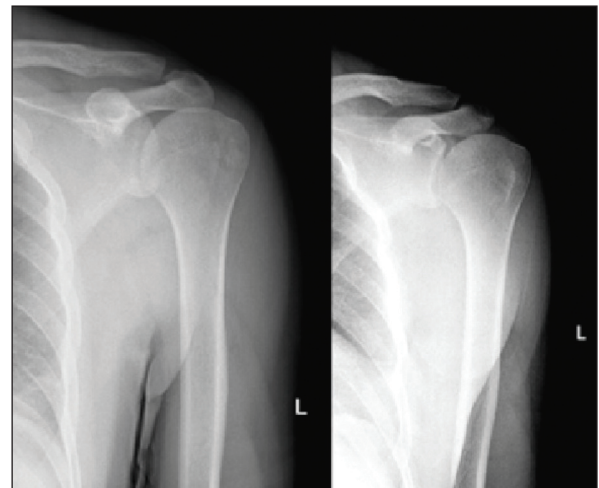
Preoperative shoulder radiographs.
